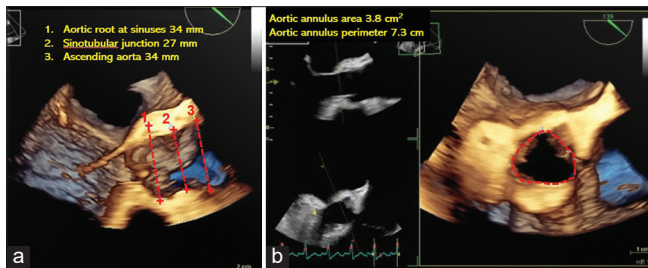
Three-dimensional transesophageal echocardiographic measurement of aortic root dimensions. (a) Diameter measurement of aortic root at the sinus of valsalva, sinotubular junction and ascending aorta, (b) Measurement of aortic annular area and perimeter
